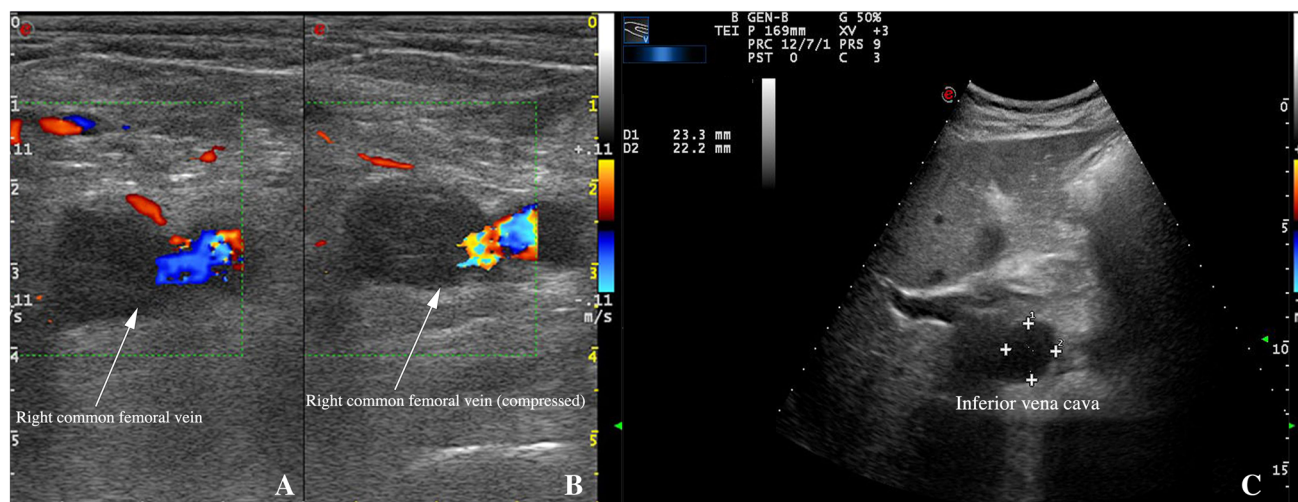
Colour assisted (a) and colour assisted compression (b) ultrasound examination of the lower limbs in the reported patient showing deep venous thrombi in the right common femoral vein; normal deep venous vessels in an otherwise healthy 35-year-old patient (c)
